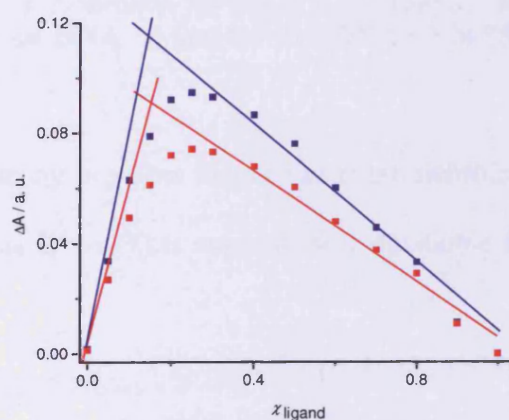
UV-visible Job plot for 5.4 interacting with CT-DNA, in buffer (25 mM MOPS, 50 mM NaCl and 1 mM EDTA), pH 7.0, at 25 °C. The changes in the absorbance at 380 (■) and 400 (■) nm wavelength are plotted against the mole fraction of the ligand χ_{ligand} .
